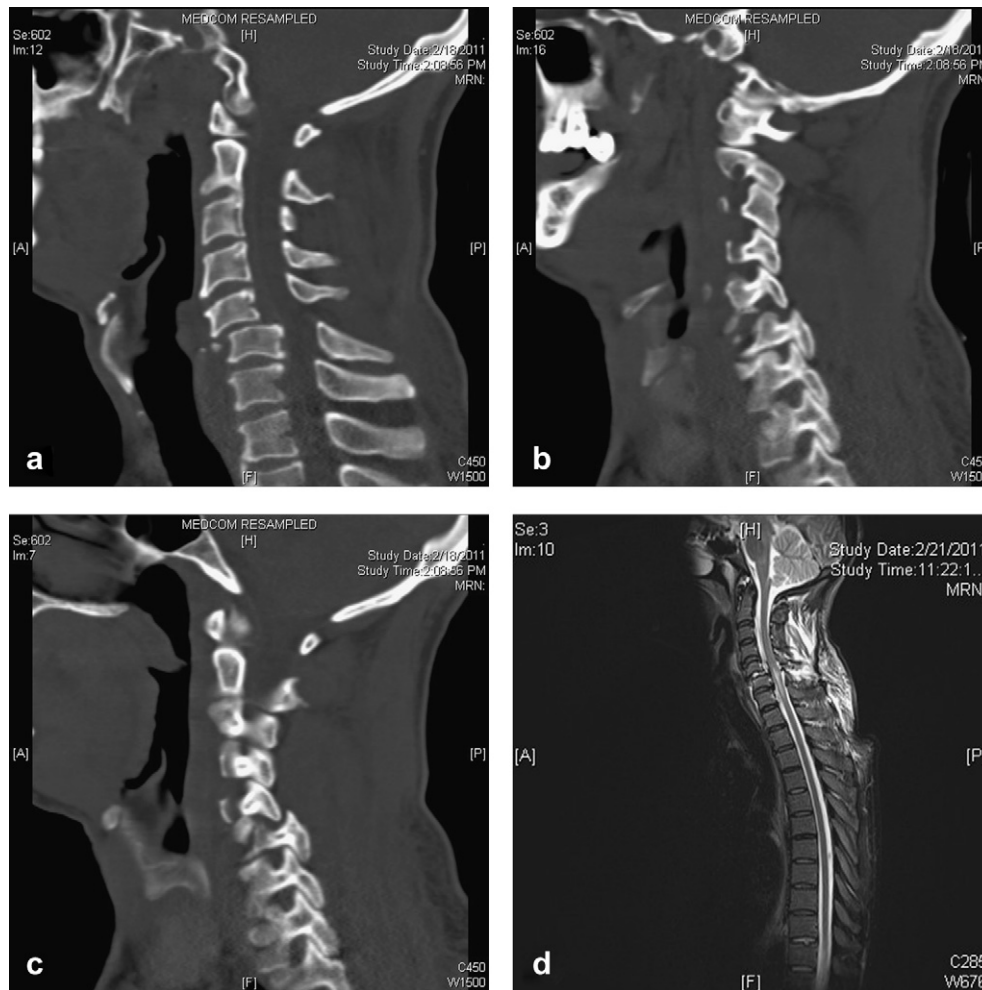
Preoperative imaging. a. Sagittal CT scan images showing anterolisthesis of C5 over C6. b & c. Right and Left parasagittal sections showing bilateral facet dislocations. d. Saggittal MRI T2W images showing thecal sac compression with cord signal changes.
